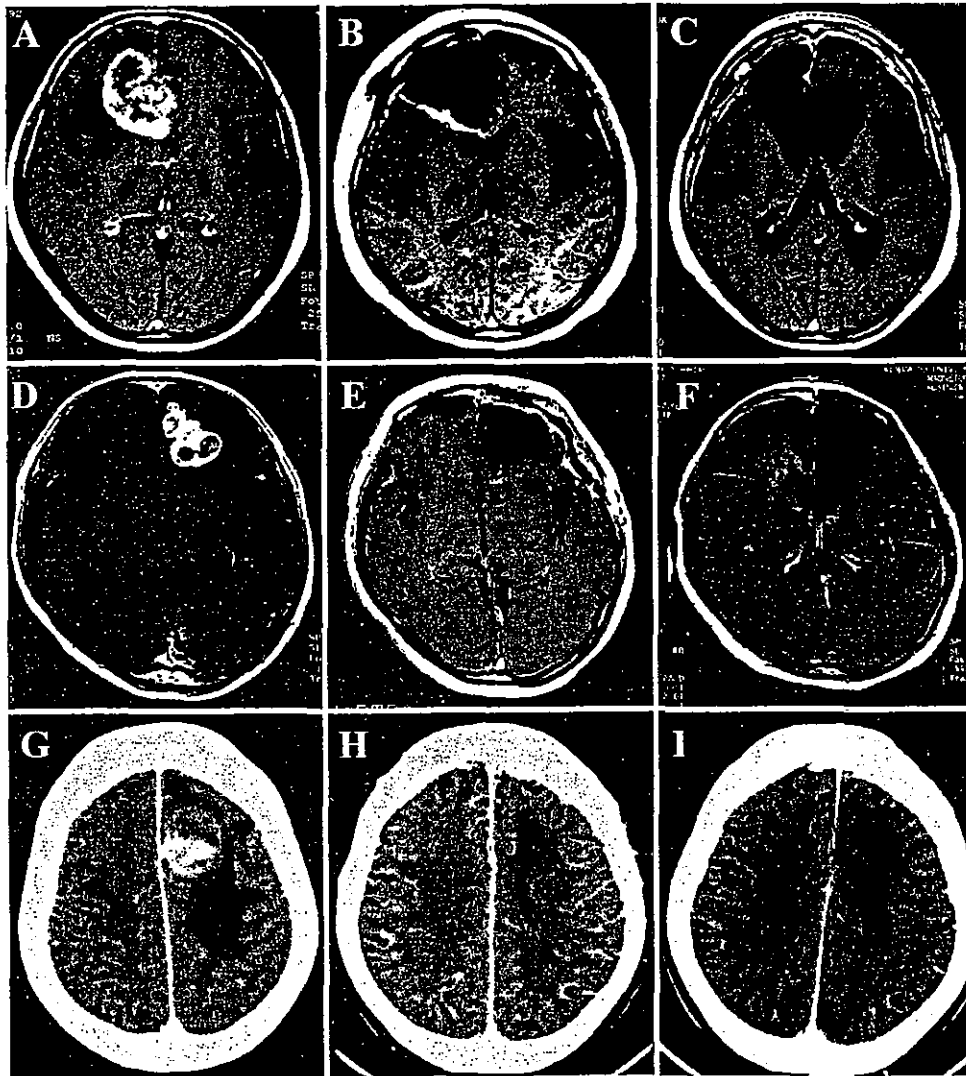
Contrast-enhanced CT and MR images. A–C: Case 3. Note the irregularly shaped ringlike enhanced mass lesion with peritumoral edema on this preoperative image (A). Following gross-total resection an area of hyperintensity at the bottom of the resection cavity is a local postoperative change (B). Six years after gross-total resection there is a marked brain cortical atrophy (C). D–F: Case 4. The left frontal tumor (D) was totally resected (E). Enhanced lesions in the right frontal lobe were visualized 7.5 years later (F) and tumor recurrence was confirmed by biopsy. G–I: Case 6. The left frontal tumor (G) was totally removed (H), and there was no sign of tumor recurrence 5 years later (I).
